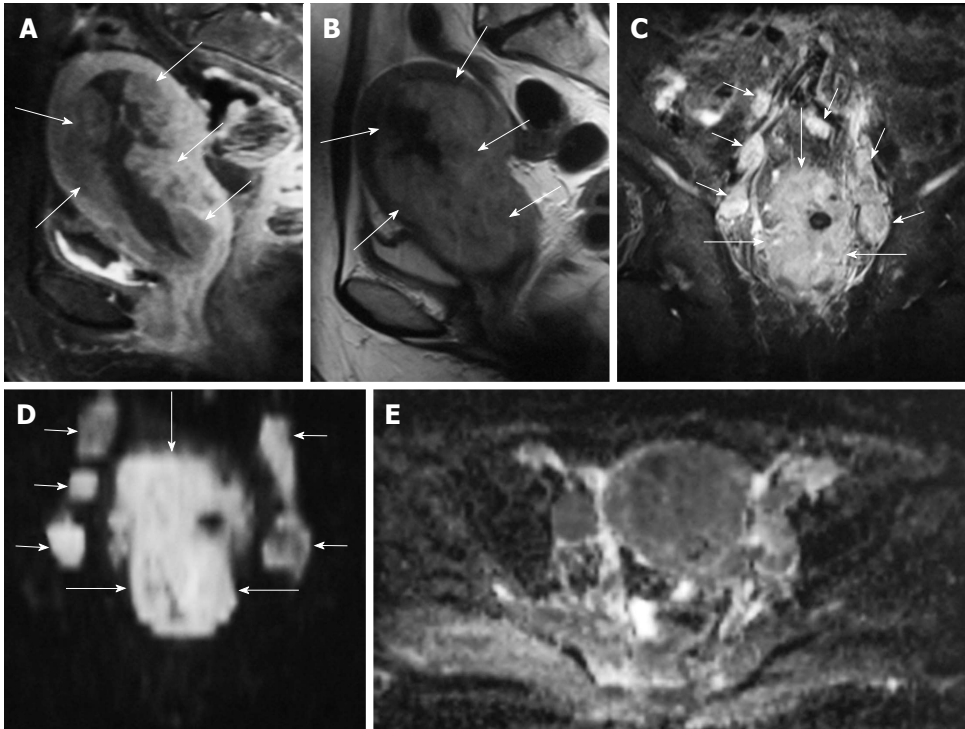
A 57-year-old woman with endometrial carcinoma. A: Sagittal contrast-enhanced T1-weighted image with fat suppression shows enhancing endometrial cancer with infiltration of myometrium (arrows); B: Sagittal T2-weighted image demonstrating hyperintense endometrial cancer with infiltration of myometrium (arrows); C: Coronal fat suppressed T2-weighted image reveals a tumor in the corpus uteri (long arrows), and bilateral metastatic lymphadenopathies along the iliac chains (short arrows); D: Coronal DWI ($b = 1000 \text{ s/mm}^2$) shows a marked hyperintense tumor in the corpus uteri (long arrows), and bilateral metastatic lymphadenopathies along the iliac chains (short arrows); E: Axial apparent diffusion coefficient map reveals the right sided metastatic lymph node and endometrium with restricted diffusion.
